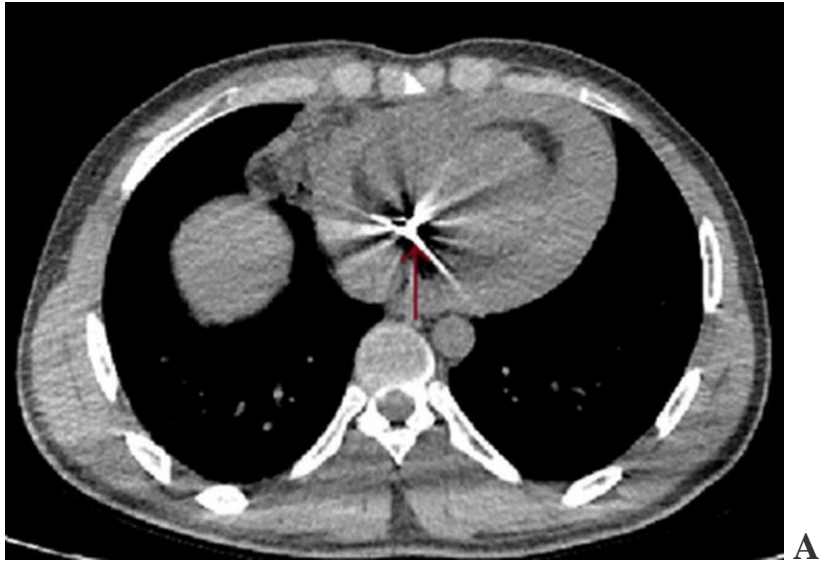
Chest CT shows a bullet (hyperdense material) in the pericardial sac with pericardial effusion. A - transverse view; B - sagittal view.
